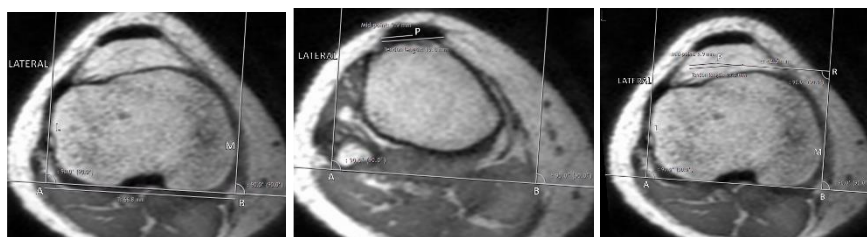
Measurement of lateralisation of patellar tendon insertion on MRI. (a) Posterior tibial condylar line AB was drawn. Lines BM and AL were drawn perpendicular to this line and passing tangential to the medial and lateral borders of the proximal tibia. The perpendicular distance between these two lines gave the width 'T' of proximal tibia. (b) Another axial section at the level of complete insertion of patellar tendon was chosen. The midpoint of patellar tendon, point 'P', was defined. (c) The perpendicular distance 't' of this point P was measured from the previously defined line BM.
